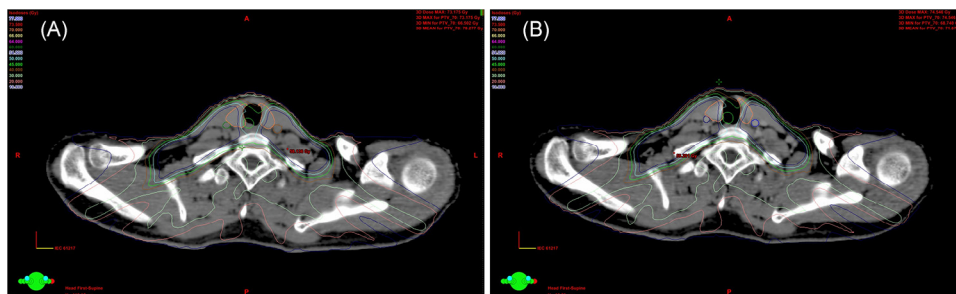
Isodose distribution of IMRT plans of the same patient showing the radiation doses to the common carotid arteries and the thyroid. (A) NCE-CT images after dose recalculation without optimization from the IMRT plan generated from (B) CE-CT images. (Color version of figure is available online.)
